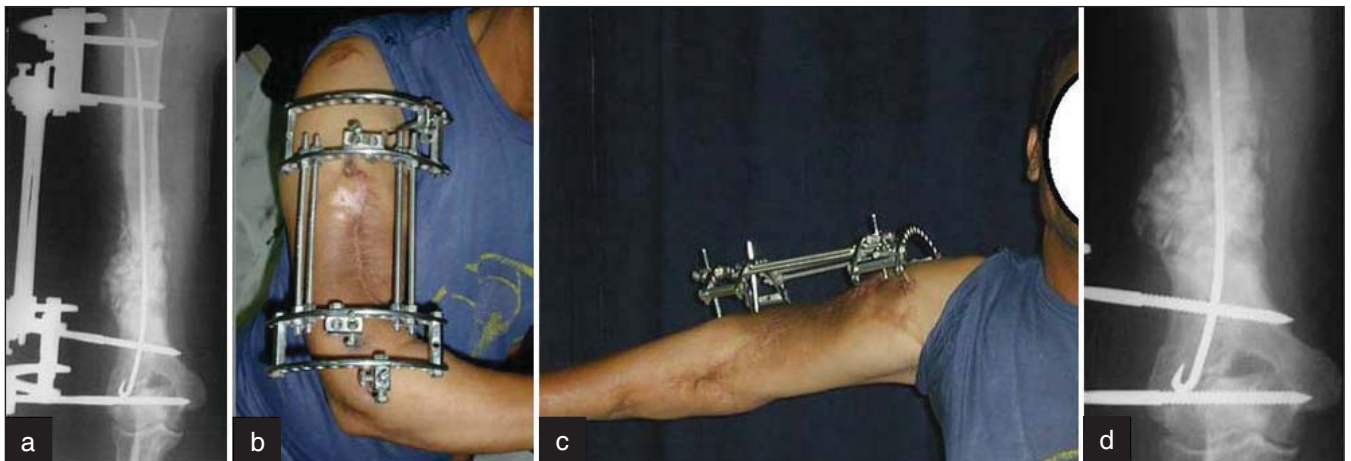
(a) A lower third humerus nonunion in a 47-year-old patient treated by Rush rod fixation combined with a modified Ilizarov fixator and autogenous bone graft (The nonunion developed after an open fracture sustained in a blast injury with radial nerve paralysis treated previously by tendon transfers). (b, c) Photographs of the same patient showing the functional use of the arm during treatment with the fixator in place. (d) A radiograph shortly before fixator removal shows incorporation of the graft
